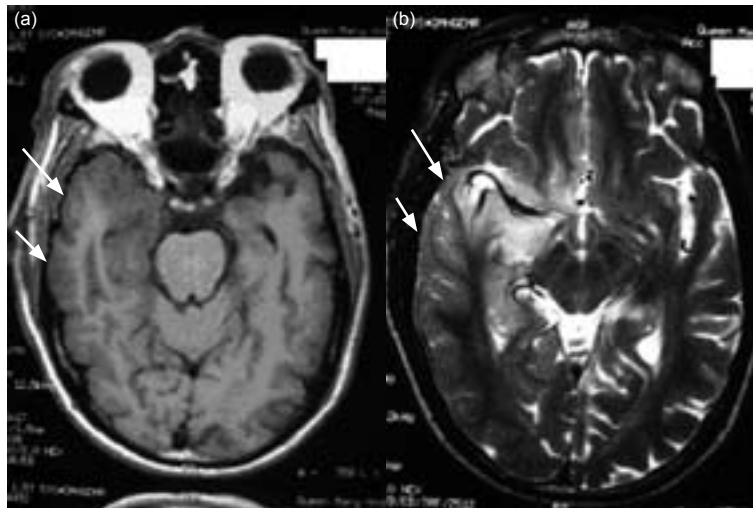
(a) T1-weighted magnetic resonance imaging (MRI) showing hypointense lesions in the medial and posterior right temporal lobe, right inferior frontal lobe, right sub-insular, external capsule and the right thalamus (arrows). (b) T2-weighted MRI showing hyperintense lesions in the medial and posterior right temporal lobe, right inferior frontal lobe, right sub-insular, external capsule and the right thalamus (arrows)
